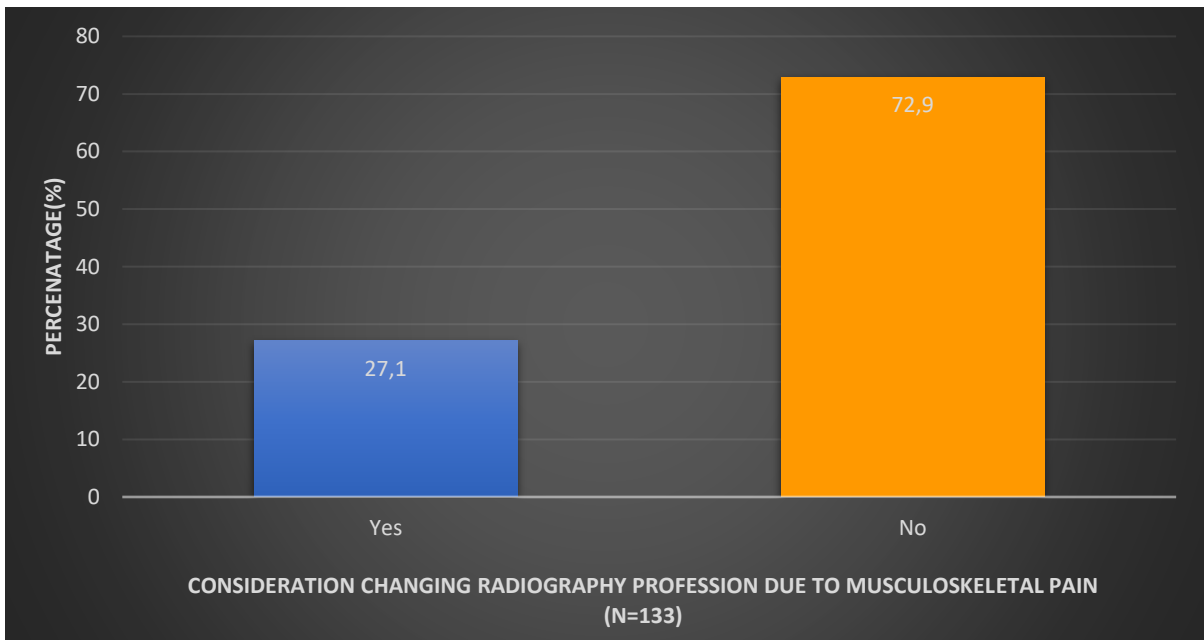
show the number of respondents considering changing the radiography profession due to musculoskeletal pain
